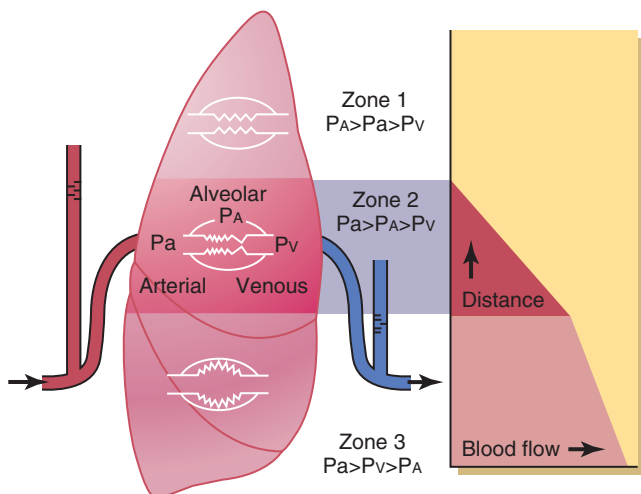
Zonal model of blood flow in the lung. Because of the inter-relationship of arterial (P_a) and venous (P_v) vascular pressures and alveolar (P_A) pressures, the lung base receives the most flow (see text for explanation). (From West JB, Dollery CT, Naimark A: Distribution of blood flow in isolated lung: relation to vascular and alveolar pressures, *J Appl Physiol* 19:713–724, 1964.)
